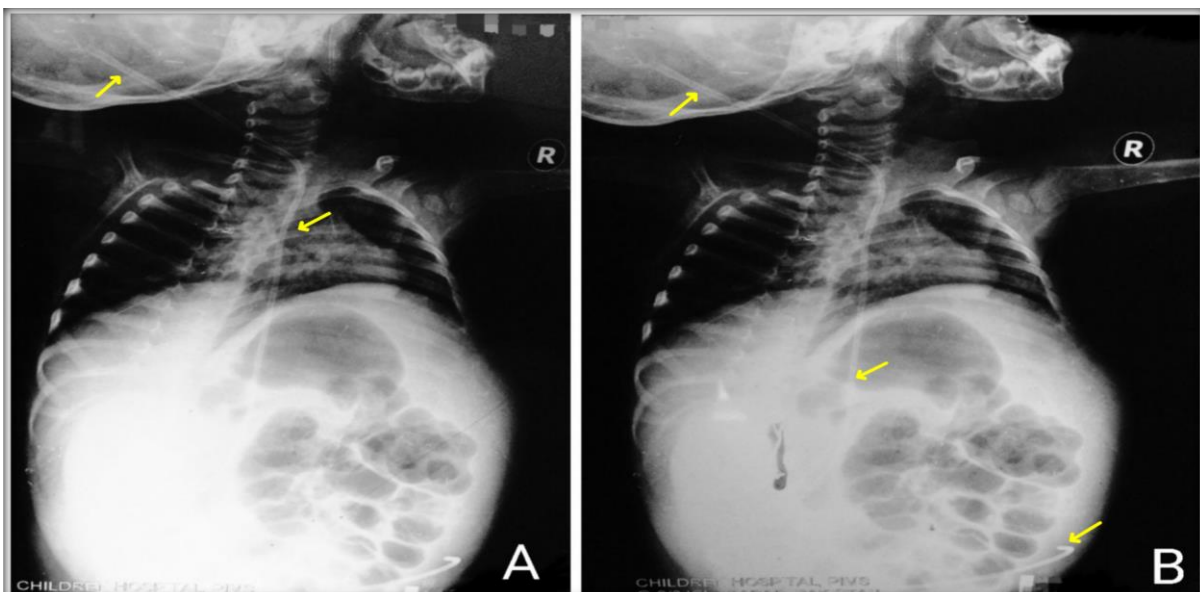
A & B: X-ray shunt series showing VP shunt tubing marked by yellow arrows
